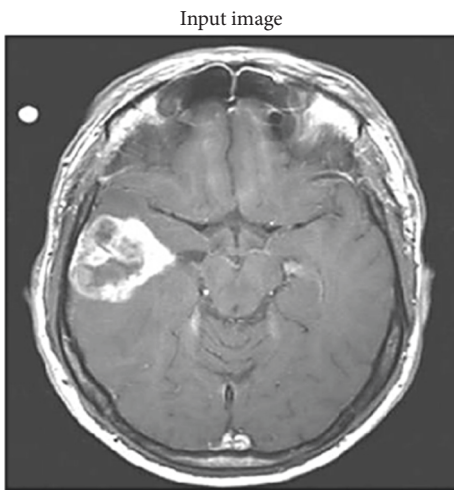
Imported input MRI image from the dataset.
